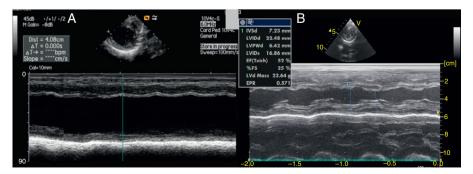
M-mode parasternal short-axis echocardiographic views: (A) enlarged left ventricle with hypokinesia on admission; (B) after 25 days of treatment, left ventricular diameters and contractile function are completely normal.
